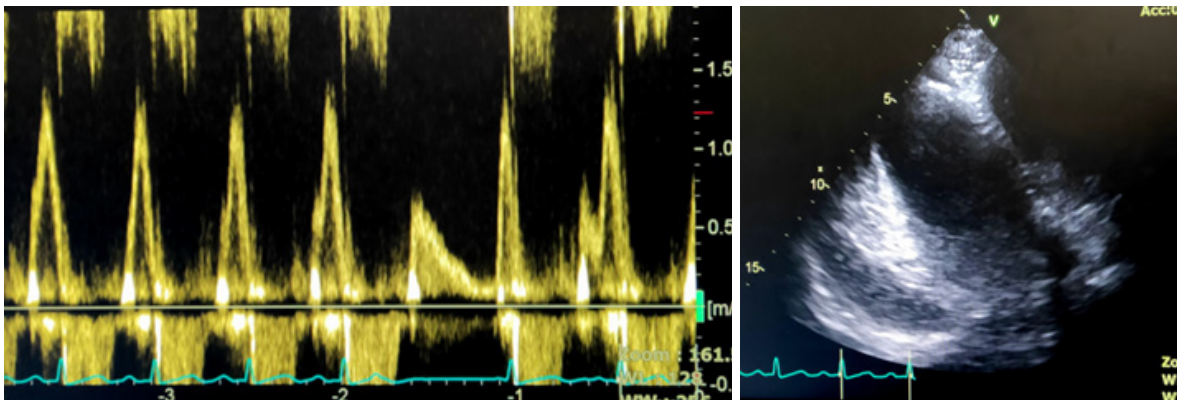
(A) Pulsed doppler echocardiography of the mitral inflow showing E-A wave fusion and a vagal event with decreased HR and shortened PR interval (ectopic junctional beat). (B) Pleural effusion seen on echocardiogram.
